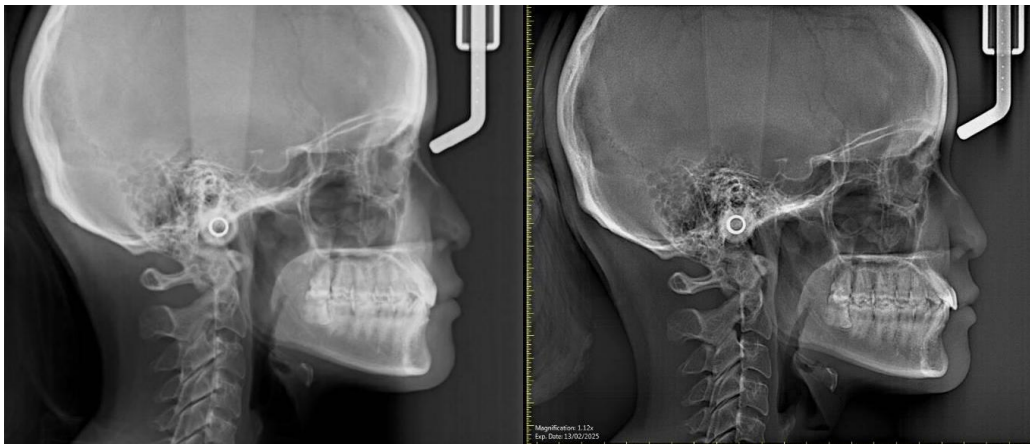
Cephalometric radiograph before and after treatment
